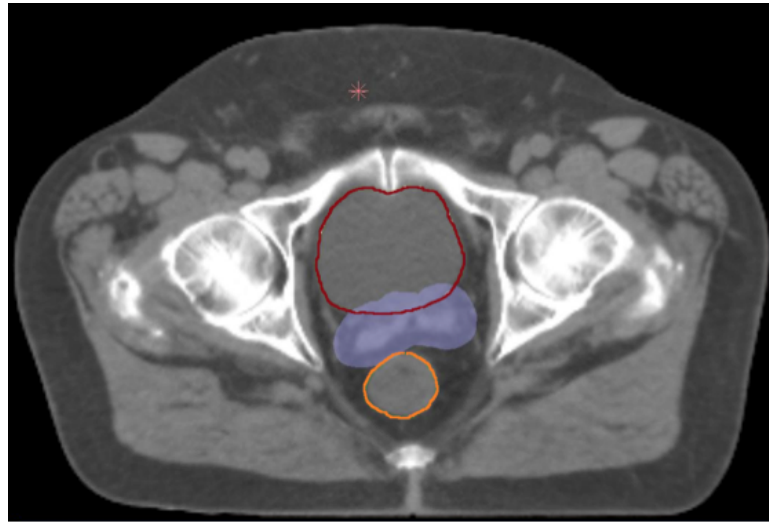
A CT scan of a patient diagnosed with prostate cancer, where Bladder (red), Rectum (orange) and PTV (purple) are represented. [This image is used under permission of the Hospital Universitario Puerta de Hierro Majadahonda, Madrid, Spain].
